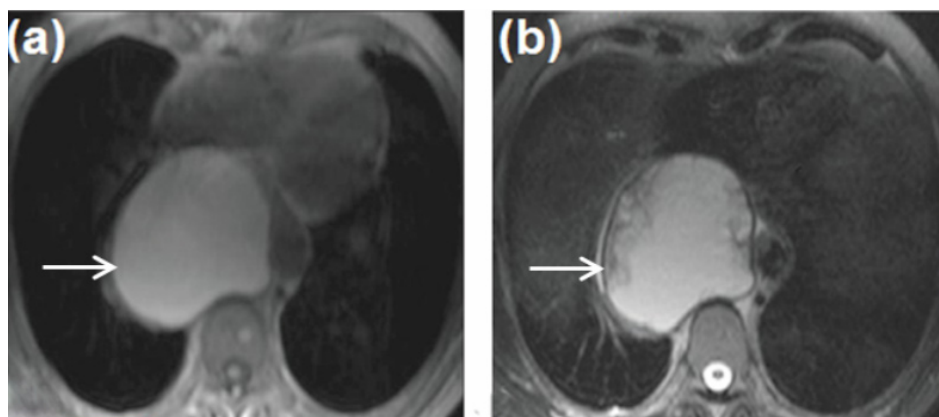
Axial MR images of a bronchogenic cyst: (a) T1-weighted image showing posterior mediastinal lesion with an increased signal intensity (arrow), and (b) T2-weighted image confirms the cystic nature of the lesion with a well-defined wall (arrow).
